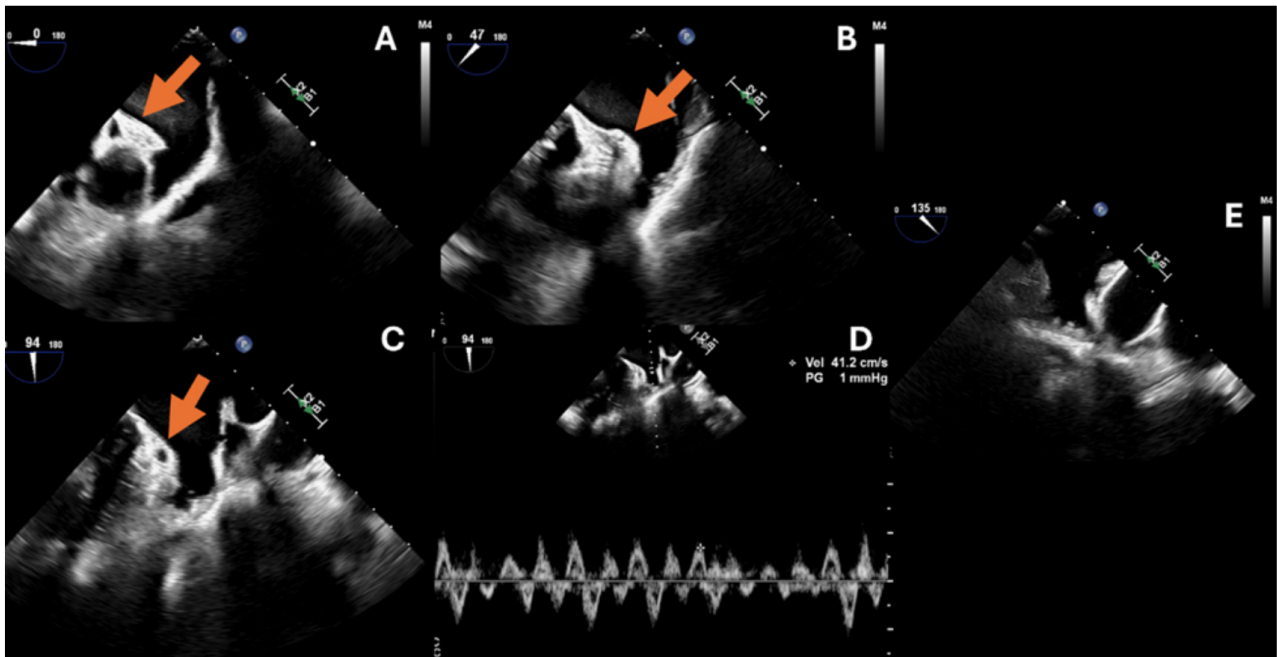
Transesophageal echocardiography (TEE) acquisition of the left atrial appendage. Views taken on multiple angles to ensure there is no LAA thrombus. (A) LAA at 0 degrees. (B) LAA at 47 degrees. (C) LAA at 94 degrees. (D) Emptying velocity obtained by pulsed-wave Doppler. This emptying velocity is >40 cm/s suggestive of good emptying velocity. (E) LAA at 135 degrees (there are trabeculation at the apex seen which are pectinate muscles). The orange arrows point toward the LAA.
